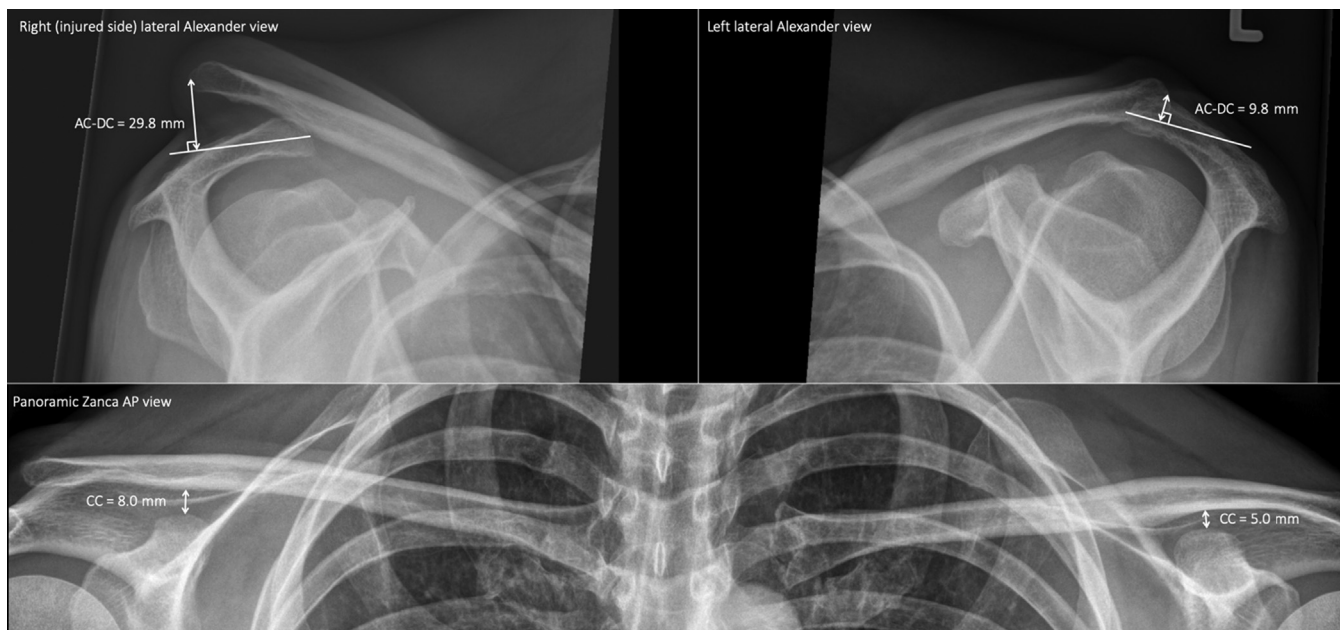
Clinical case radiographs: panoramic Zanca AP view and lateral Alexander views of the injured right side and uninjured left side. It was subjectively judged as Rockwood IV. Difference between left and right CC distance = 3 mm and AC-DC = 20 mm. AC-DC, acromial center line to dorsal clavicle; AP, anteroposterior; CC, coracoclavicular.
